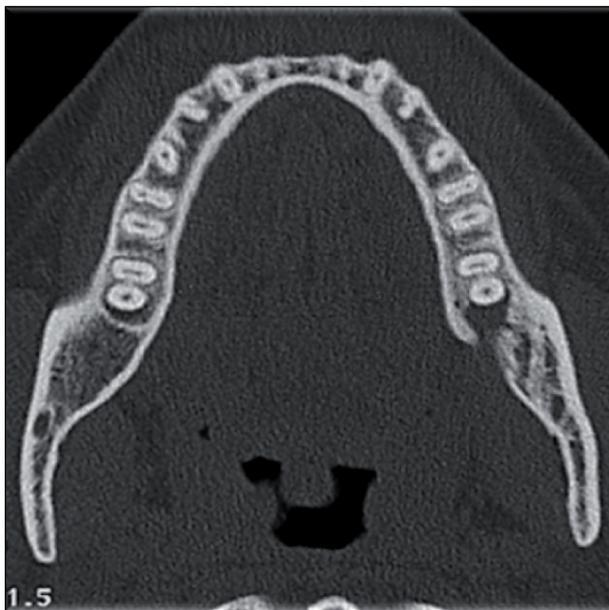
Axial CT-scan showing the damage of the lingual mandibular cortical.
